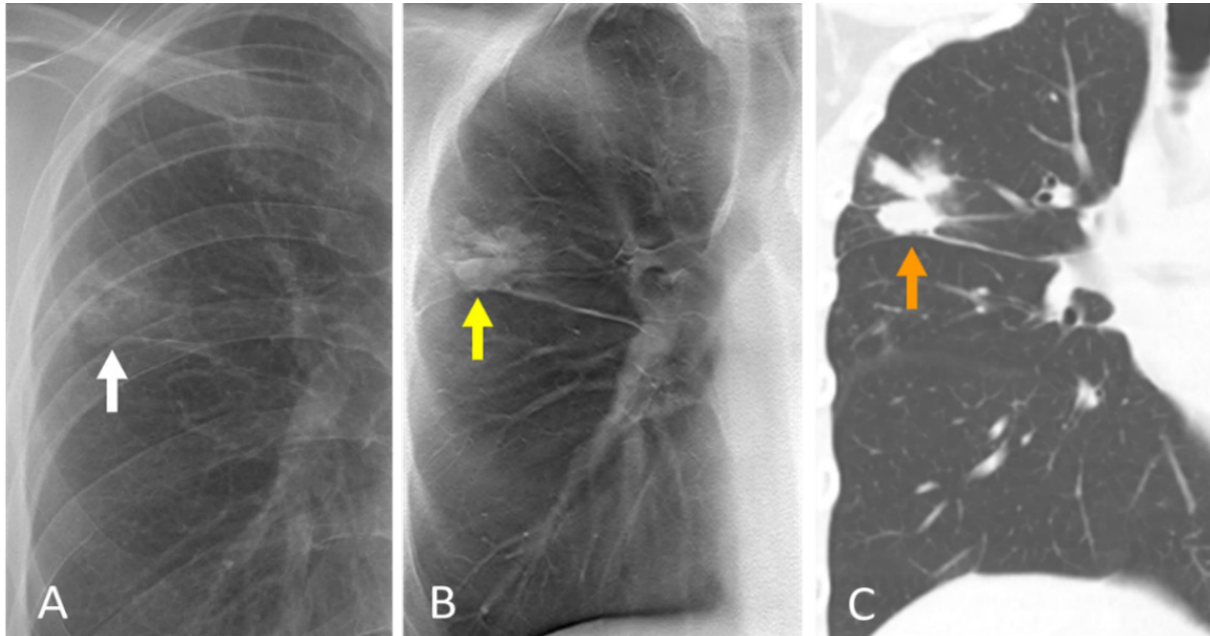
Detection of patchy consolidation on digital tomosynthesis: a 27-year-old male patient diagnosed with MDR TB. Suspicious focal patchy consolidation is seen in the right upper lung zone on the chest radiograph (arrow in A). The patchy consolidation is more clearly visible on digital tomosynthesis (arrow in B) in the right upper lobe than in the chest radiograph. Coronal chest CT imaging on the same day confirms this lesion as a patchy air-space consolidation in the right upper lobe (C).*
